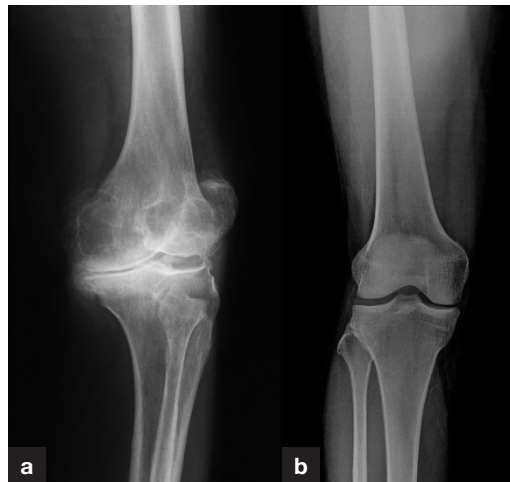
Plain radiographs of (a) osteoarthritic knee and (b) non-arthritic knee.
